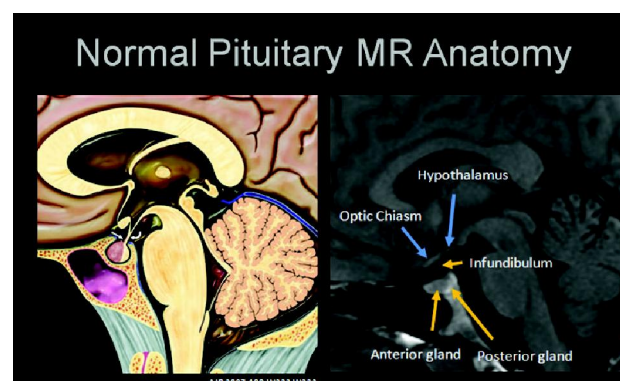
(T1 and T2 sagittal and coronal MRI demonstrating the normal pituitary gland & sella)
